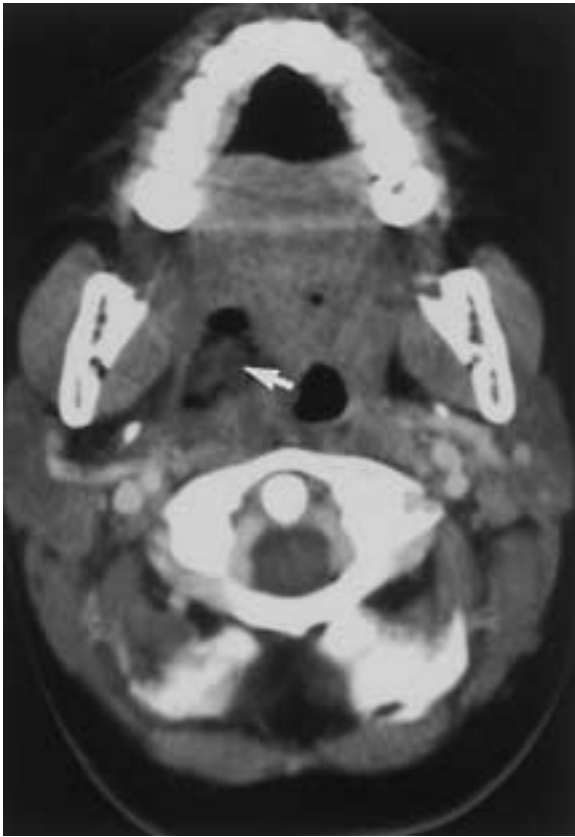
Penetrating injury to the tonsil in a 10-year-old child. On contrast-enhanced CT there is gas and low-attenuation change within the right tonsil indicating the trajectory of the injury (*arrow*).
